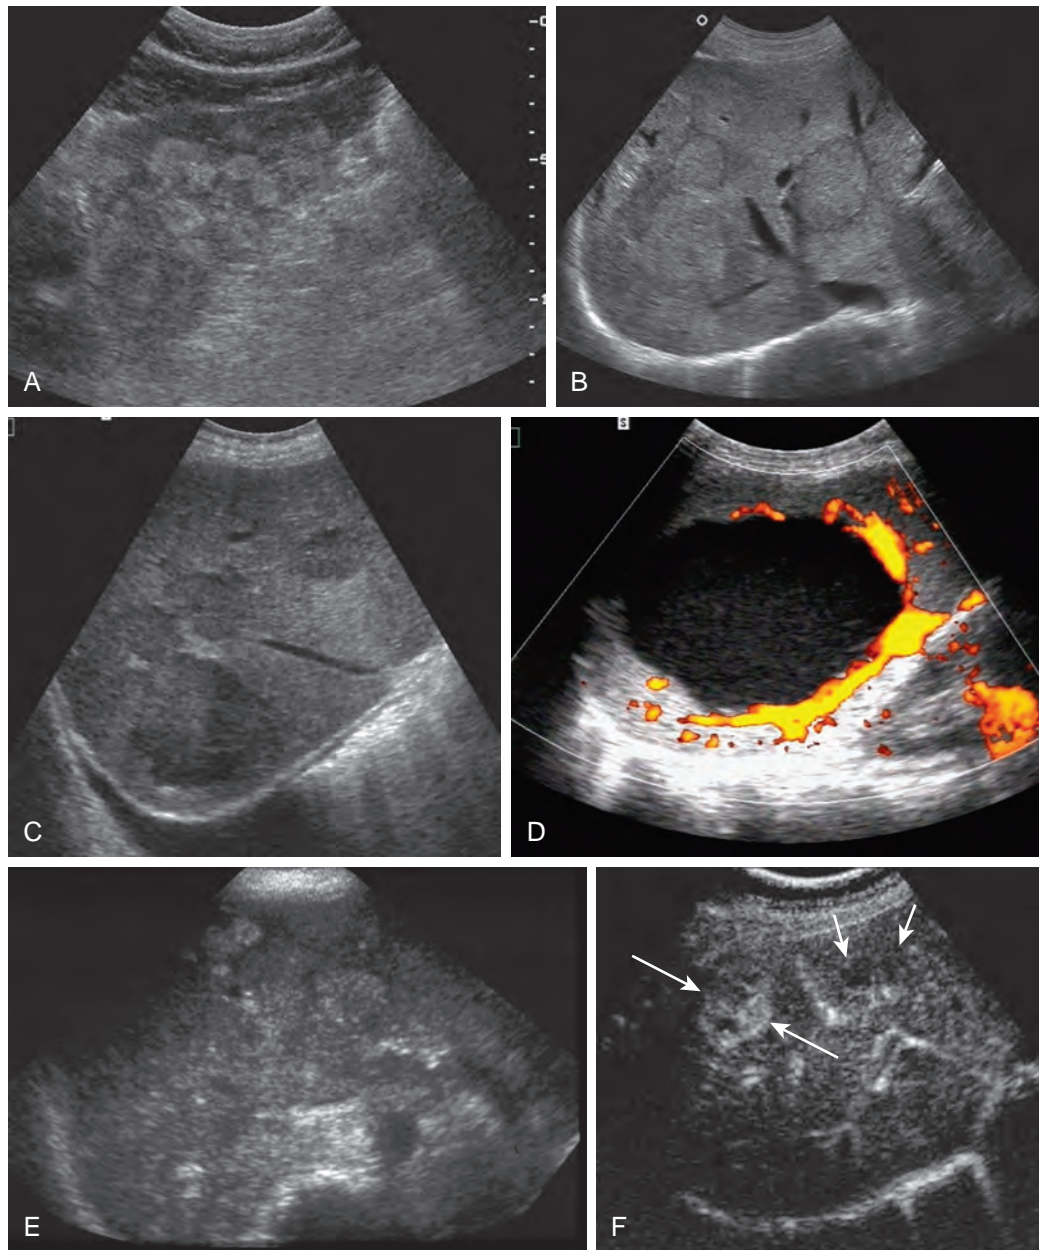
Hepatic metastases: spectrum of sonographic findings. A. Hyperechoic metastases are seen on this sagittal scan of the left hepatic lobe in a patient with carcinoid tumor. B. Bull's-eye lesions are present on this axial scan in a patient with metastatic lung cancer. C. Hypoechoic metastases are demonstrated in this patient with pancreatic cancer. There is a pleural effusion as well. D. Cystic metastasis with multiple fine internal echoes is present in this patient with mucinous ovarian carcinoma. E. Calcified metastases are seen in this patient with mucinous colon carcinoma. F. Hypervascular liver metastases in a 60-year-old man with previously resected retroperitoneal sarcoma. Early arterial phase ultrasound image (F) obtained 20 seconds after contrast material injection shows a large lesion with heterogeneous and mostly peripheral (nonglobular) enhancement (large arrows). Two small lesions remain hypoechoic (small arrows). (F from Catalano O, Nunziata A, Lobianco R, et al: *Real-time harmonic contrast material-specific US of focal liver lesions*. *RadioGraphics* 25:333–349, 2005.)
